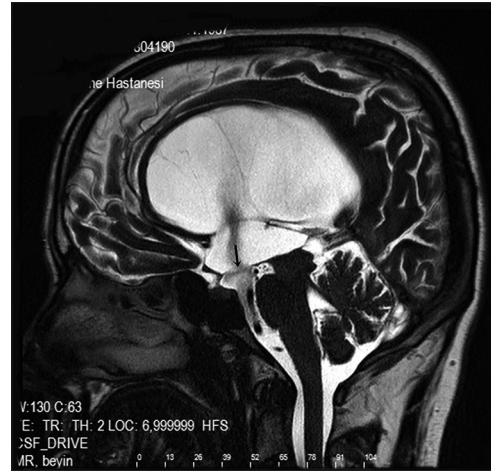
Postoperative sagittal CSF_DRIVE T2 secans magnetic resonance imaging demonstrating a third ventriculostomy patency (black arrow). Continuous (patent) cerebrospinal fluid flow is observed from the foramen of Monro to the prepontine cistern. Superior to inferior flow is shown in black
